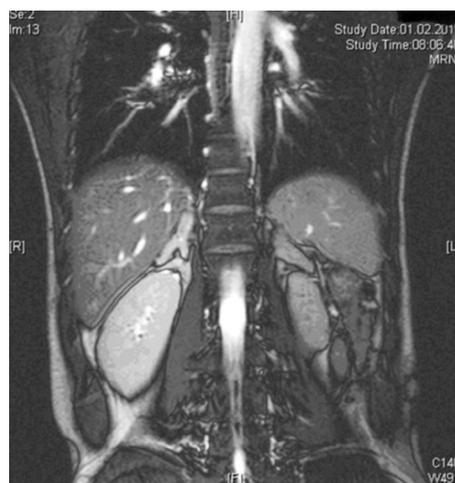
Congenital adrenal hyperplasia associated with 11-β hydroxylase deficiency: pronounced bilateral adrenal hyperplasia on a subrenal magnetic resonance image from Case 1.
